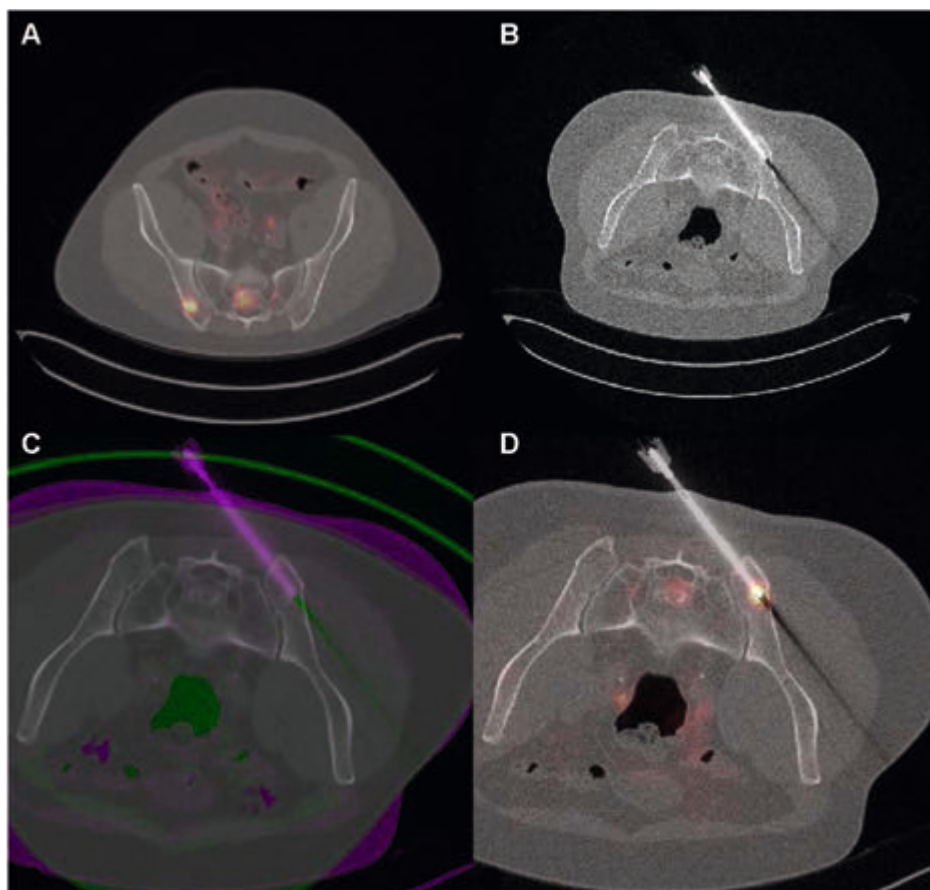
Rigid-body image registration of ⁶⁸Ga-PSMA PET/CT and interventional CT visualizes biopsy needle on ⁶⁸Ga-PSMA PET and enables measurement of ⁶⁸Ga-PSMA uptake and radiodensity at biopsy site. (A) ⁶⁸Ga-PSMA PET/CT, before biopsy. (B) CT, acquired during biopsy procedure. (C) Coregistration of ⁶⁸Ga-PSMA PET/CT and interventional CT. (D) Visualization of biopsy needle on ⁶⁸Ga-PSMA PET/CT.
